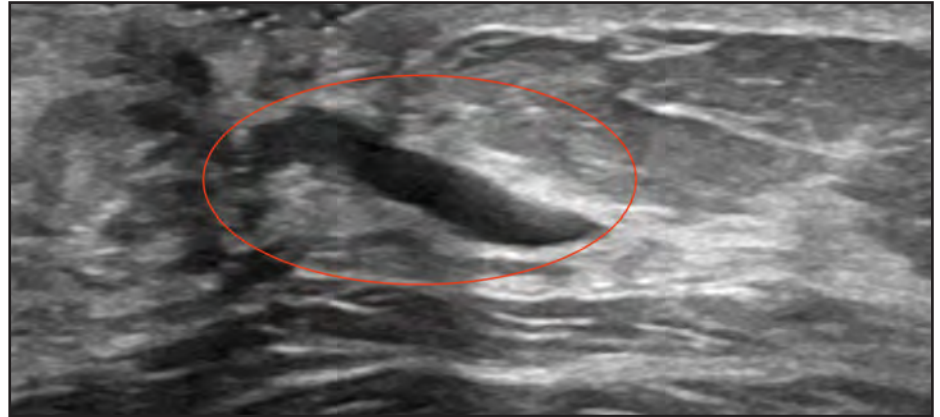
Targeted B-mode ultrasound of the subareolar region of the left breast in the transverse plane demonstrates a dilated duct with internal echoes (oval) corresponding to the mammographic finding. The differential considerations include a duct with debris vs an intraductal mass distending a duct.
